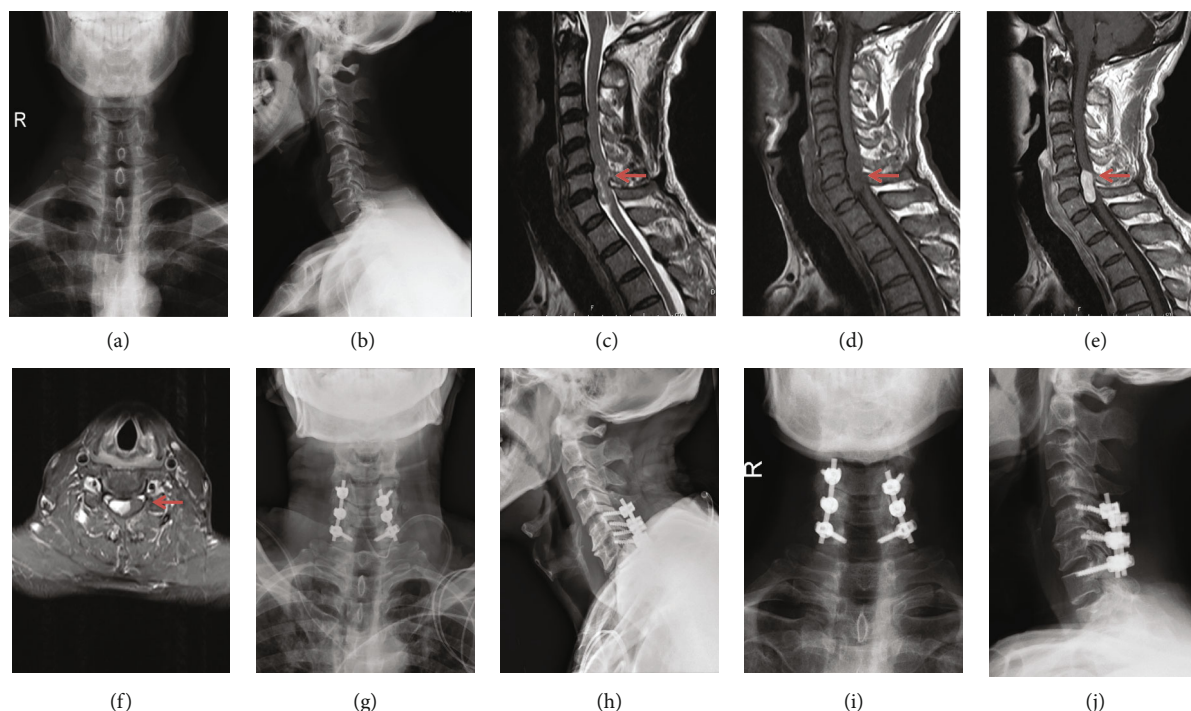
Radiological images before surgery, after surgery, and at the last follow-up. (a, b) Preoperative X-ray images; (c, d) preoperative T2- and T1-weighted MRI scan; (e, f) preoperative enhanced T1-weighted MRI scan; (g, h) postoperative X-ray immediately; (i, j) postoperative X-ray at the last follow-up.
